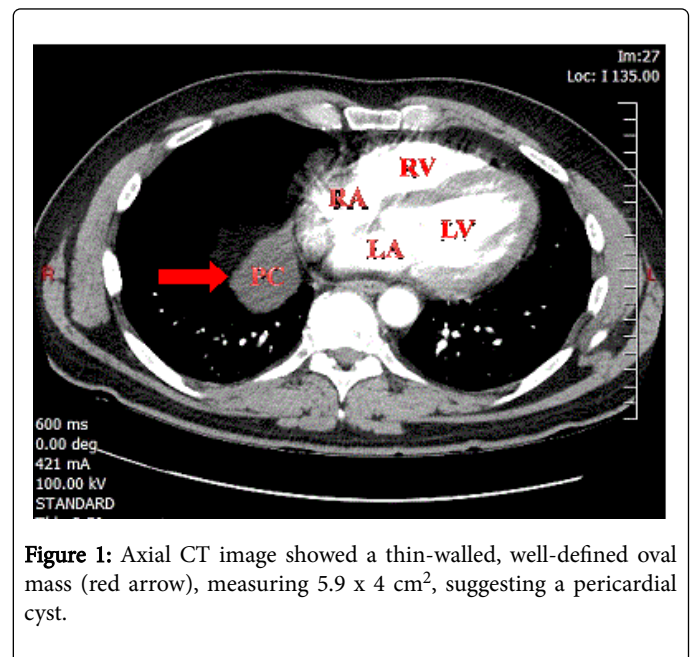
Axial CT image showed a thin-walled, well-defined oval mass (red arrow), measuring $5.9 \times 4 \text{ cm}^2$, suggesting a pericardial cyst.
